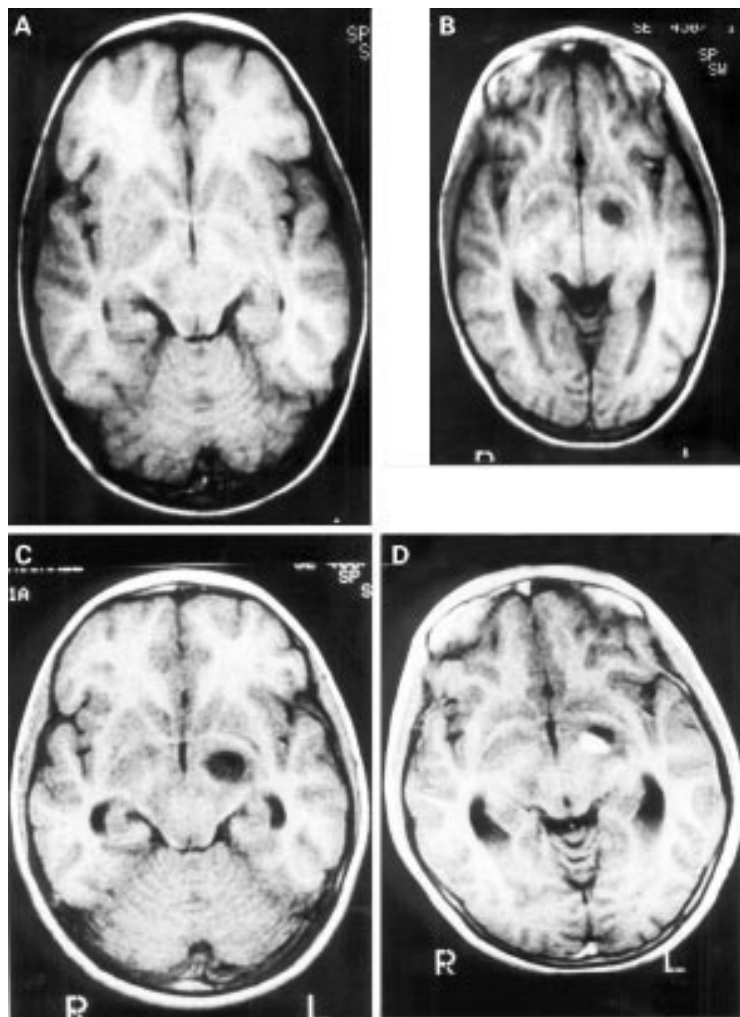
MRI, axial cuts, T1 weighted (400/10), at the level of the optic tracts. (A) Normal; (B) follow up two years later: a cystic lesion is seen on the left; (C) one year after (B) the lesion has enlarged; (D) same examination as (C) after gadolinium injection: partial enhancement of the lesion is noted.
